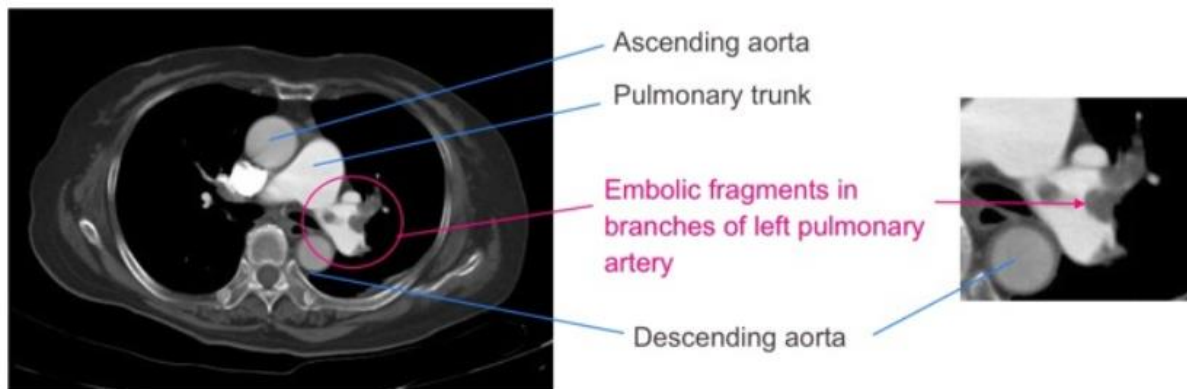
Computed Tomography Pulmonary Angiography Image (González et al., 2020)
